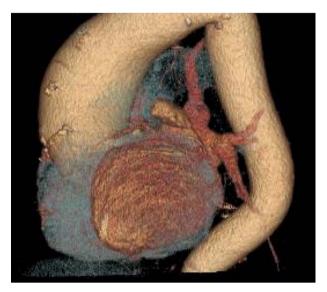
CT three-dimensional volume rendered reconstruction of thoracic aortic aneurysm.
